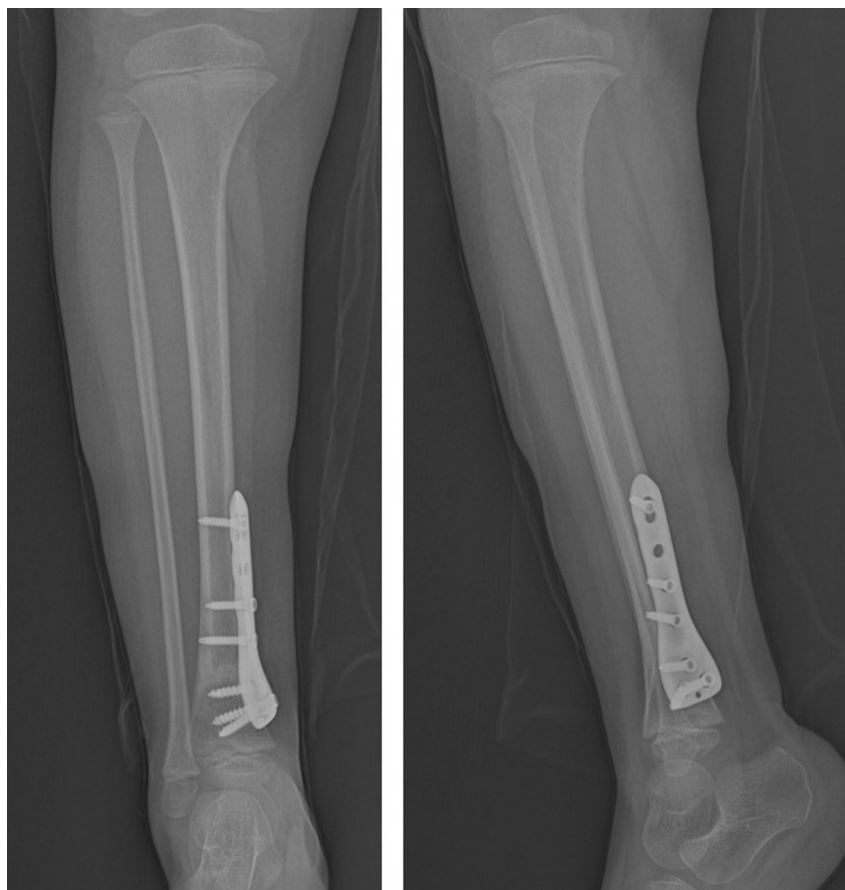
Follow up radiographs show level of osteotomy and bone fusion.
